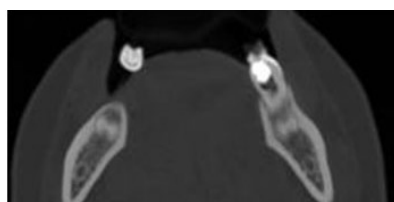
Preoperative Radiograph of Tooth # 36.
